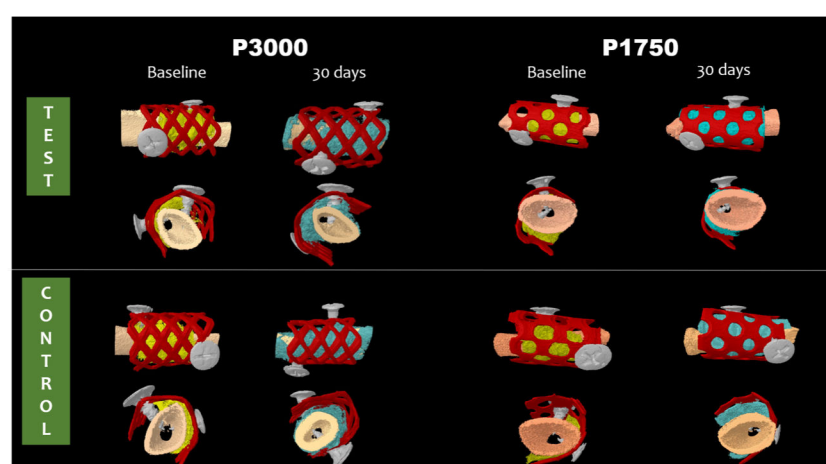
Micro CT 3D images of P3000 and P1750
